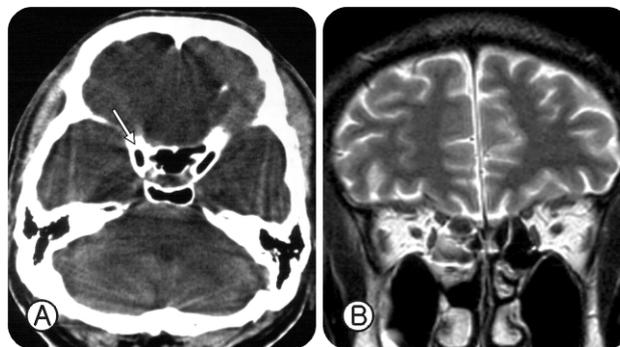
A. Paranasal CT showing profuse pneumatization of sphenoid sinus toward the anterior clinoid process. B. T2-weighted MRI showing signal change at the same site.
